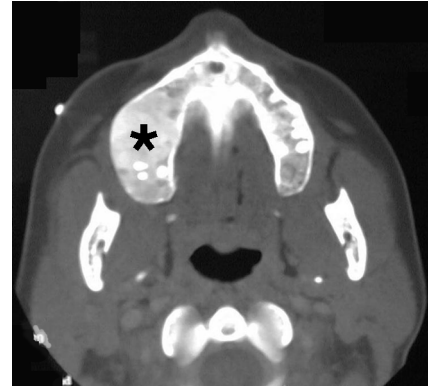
Axial CT scan of the jaw showing expansion caused by fibrous dysplasia (asterisk). (Copyright © Rakesh Donthineni-Rao, MD.)
